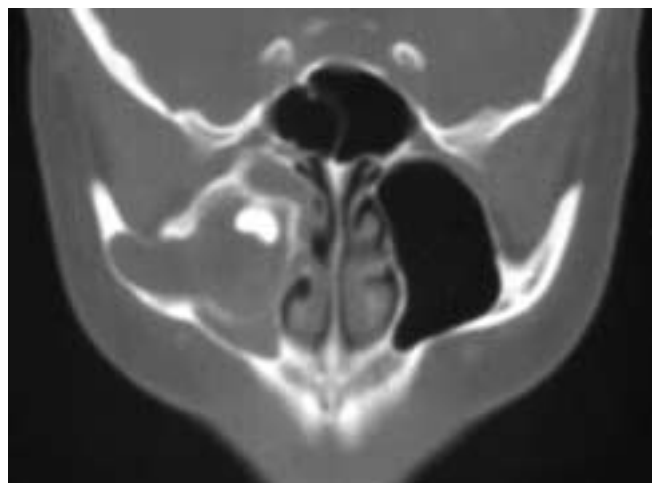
Coronal CT scan shows an expansile right maxillary sinus mass with a tooth within the antrum. This patient had a dentigerous cyst.
